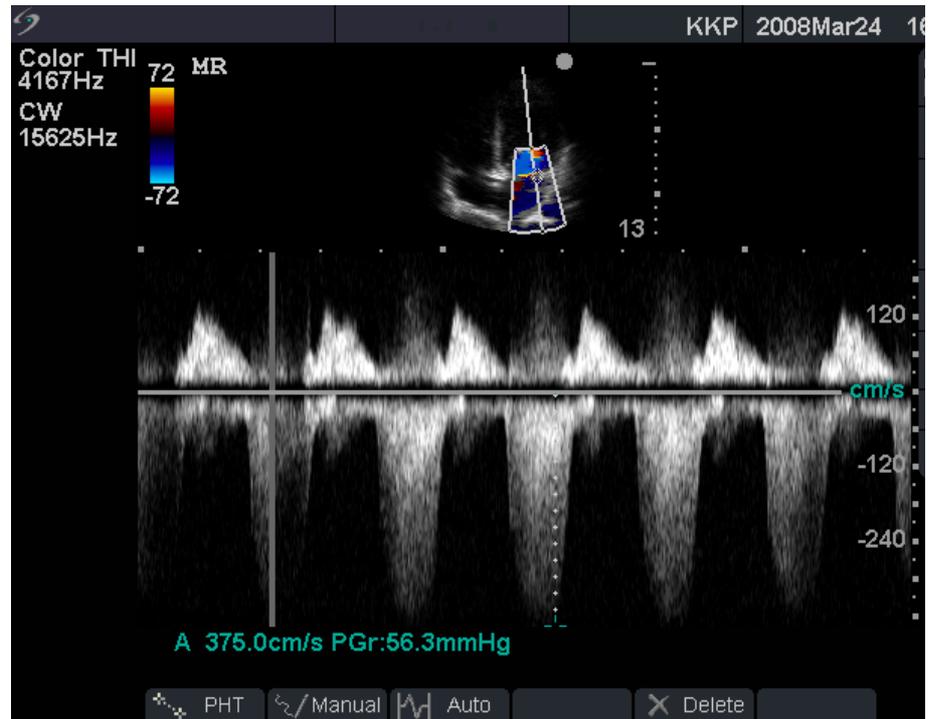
An example of Continuous Wave Doppler of a mitral regurgitation jet.
